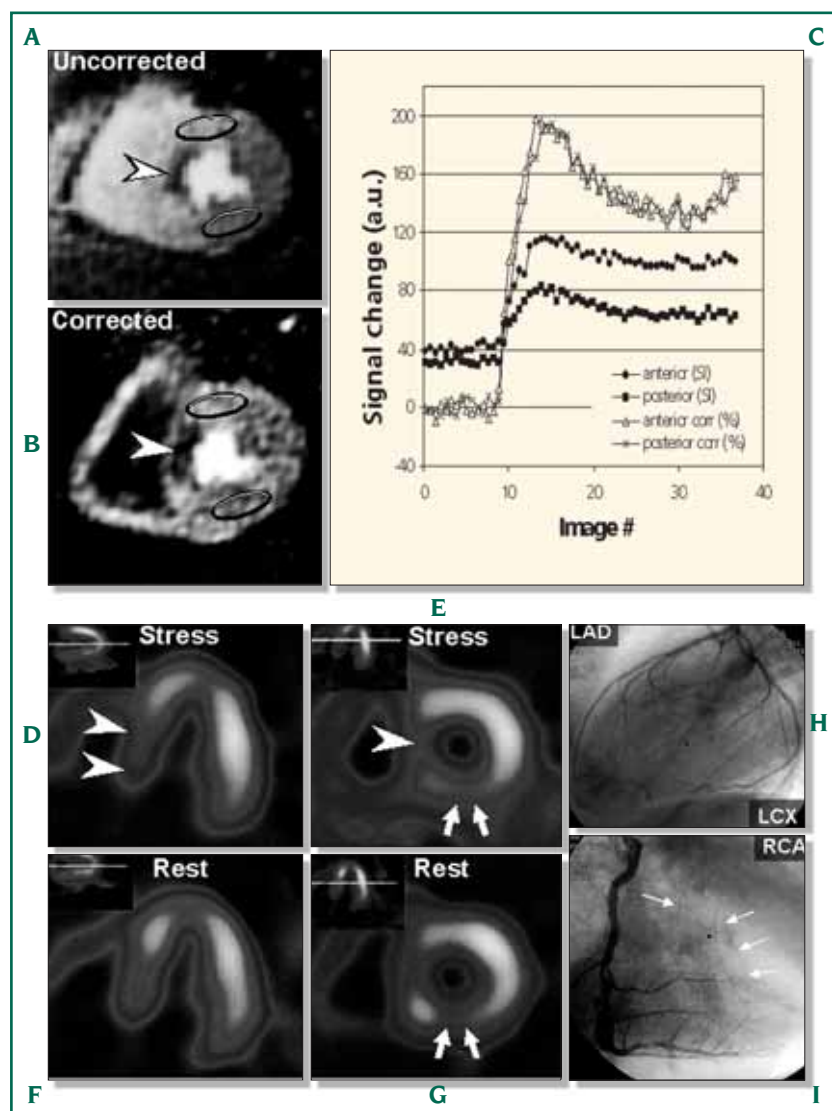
In a 47-year-old patient atypical chest pain developed 2 months after successful stent implantation into a stenosis of the left anterior descending coronary artery (LAD). Perfusion-CMR (cardiovascular magnetic resonance) demonstrates a perfusion deficit in the septal wall during hyperemia on an uncorrected magnetic resonance image (A, arrowhead) at peak effect of the contrast medium bolus. Uncorrected CMR signal intensity time curves (C, closed symbols) of the anterior and posterior walls (ellipses on MR images) show reduced peak signal in the posterior parts of the heart. Correction (by simple division through precontrast data) yields identical signal responses for the two regions (open symbols). In x-ray coronary angiography, the LAD stent showed no stenosis (H), but had compromised takeoff of septal branches. Contrast injection into the right coronary artery (RCA) demonstrates collateralization of the septum (arrows in I). A ^{99m}Tc -tetrofosmin single photon emission computed tomography (SPECT) hyperemic study (D,E) shows a perfusion deficit in the septal wall (arrowheads), but also reduced tracer uptake in the posterior wall in both rest and hyperemic SPECT studies (arrows) suggesting scar. Magnetic resonance excluded inferior perfusion abnormalities and x-ray coronary angiography confirmed normal RCA (I) and left circumflex coronary artery (H, LCX). This example demonstrates problematic attenuation in SPECT, which is not encountered in perfusion-CMR. Perfusion-CMR is also not limited by the presence of implanted stents (LAD territory).
